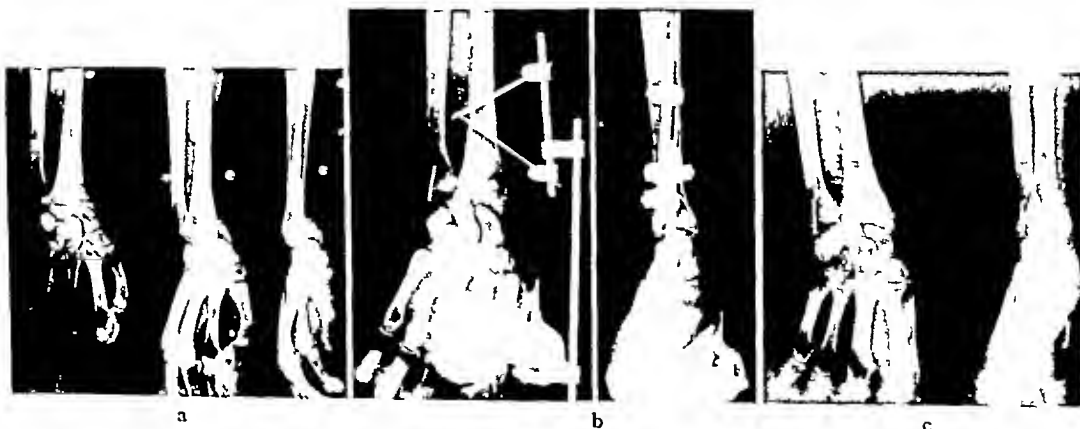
a, Mrs. A. D., November 30, 1942. b, Roentgenogram on December 7, 1942, 1 week after reduction. The fracture of the ulna was held with a small band because with her age of 50 it was thought advisable to maintain
